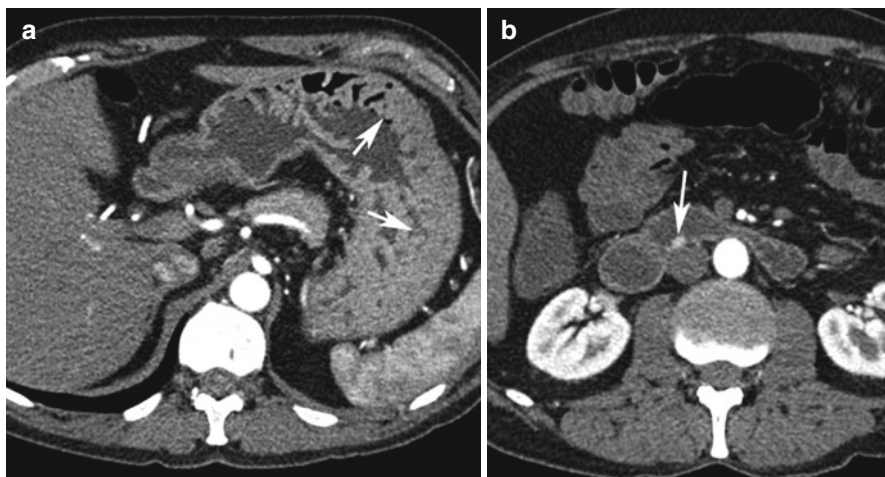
Duodenal gastrinoma. A 49-year-old gentleman presented with Zollinger-Ellison syndrome. (a) Arterial-phase CT shows generalised gastric rugal hypertrophy consistent with hypergastrinaemia. (b) A small hypervascular lesion on the posterior wall of the third part of the duodenum was identified consistent with a gastrinoma, shown here on axial CT (*white arrow*)
